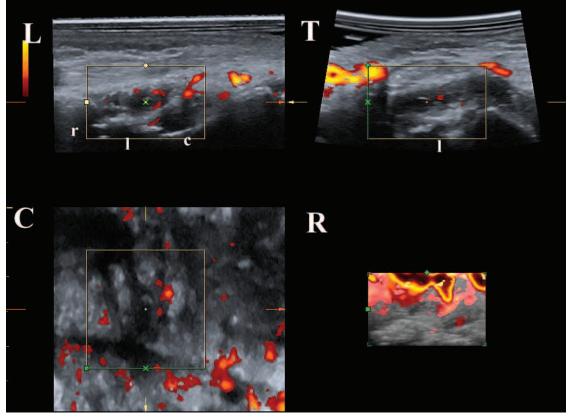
Volumetric power Doppler ultrasound image of the dorsal aspect of the radiocarpal and midcarpal joints. The longitudinal (L), transverse (T), and coronal (C) planes at the selected anatomic level of the joints and the reconstruction volume (R) are shown. Wrist was globally scored moderate on both B-mode and power Doppler mode. r: radius; l: lunate; c: capitate.
